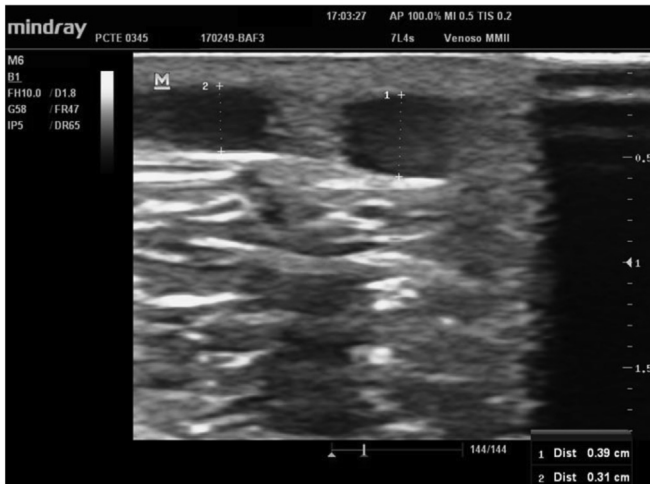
Duplex ultrasound examination.
